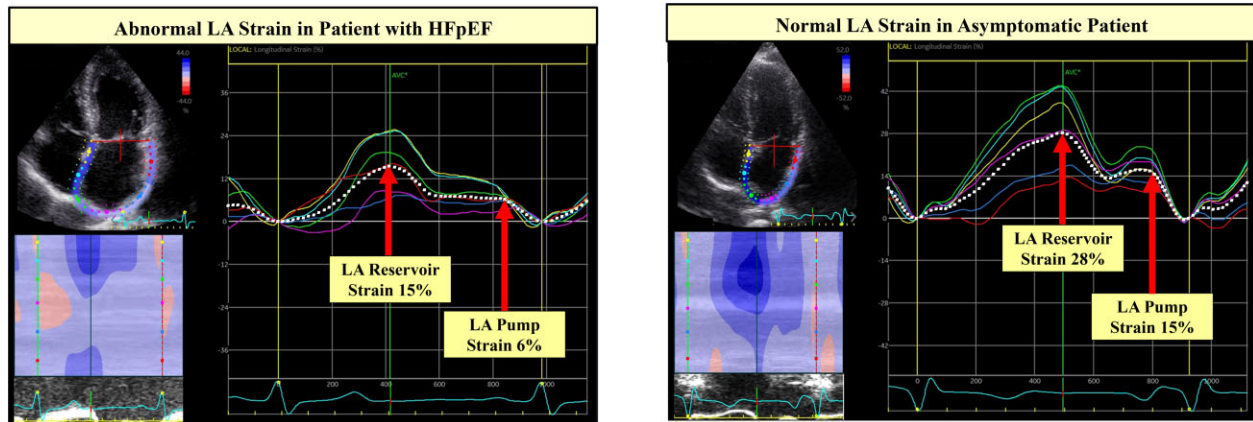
Measurement of left atrial strain in apical four-chamber view. The left panel shows a patient with HFpEF and abnormal LA reservoir and pump strains and in the right panel a patient with normal LA strains.
